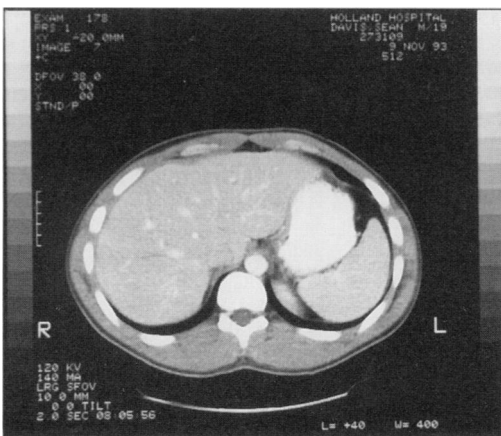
Follow-up CT scan at 1 month demonstrates significant healing.
